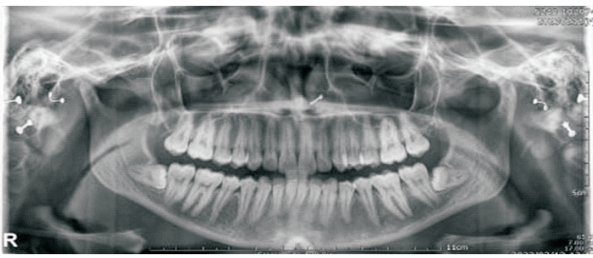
Orthopantomogram of a patient having bilaterally symmetrical impacted mandibular third molars
